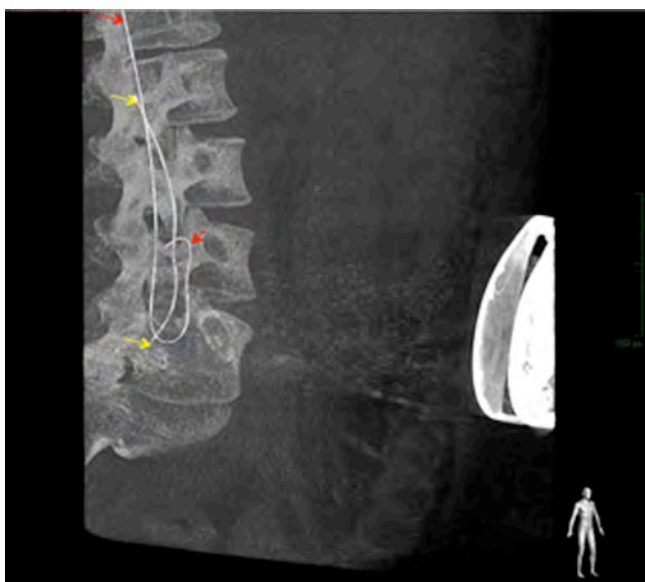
Three dimensional radiographic image of the patient showing two spinal catheter, one of which could not be removed during revision surgery. The tip of the previous catheter marked with yellow arrows whereas the new one was marked with red arrows.
